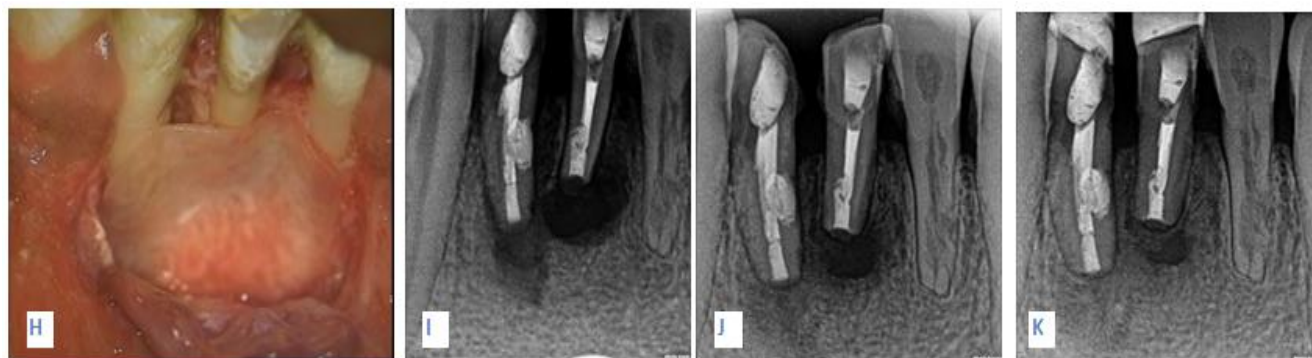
H-ketac molar and resorbable membrane application, I-3 month post op x-ray, J-6 month post op x-ray, K-12 month post op x-rays.
